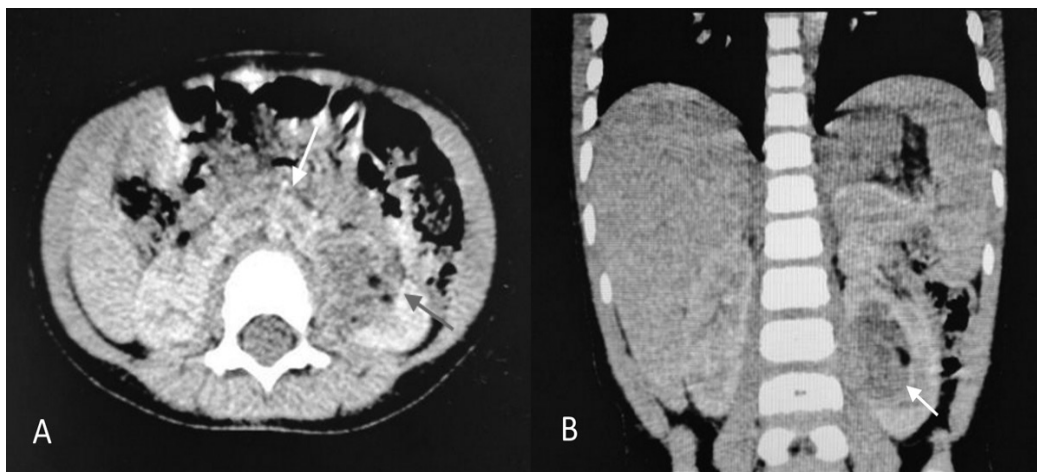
A. Axial CT scan of the abdomen at the level of L3 and L4, demonstrating the mass (gray arrow) and the inferior poles of both kidneys medially directed and connected by a homogeneously enhancing parenchymal isthmus (white arrow) located anterior to the abdominal aorta and inferior vena cava. B. Coronal CT scan of the abdomen demonstrating a heterogeneously enhancing mass in the interpolar region and inferior pole of the left kidney, measuring approximately 3.1 cm x 2.9 cm x 2.9 cm. A good plane of demarcation (white arrow) is seen between the said mass and partially compressed middle and inferior infundibulum and pelvis of the left kidney.
